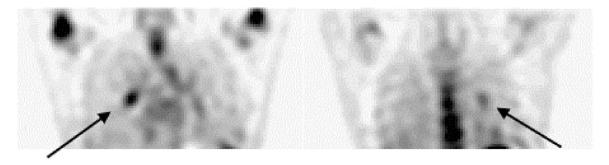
Coronal SPECT images through the mid thorax show increased accumulation of DMP-444 (99mTc-GP llb/llla antagonist) in a patient with documented pulmonary embolism (PE) within the right main and both lower lobe pulmonary arteries.
